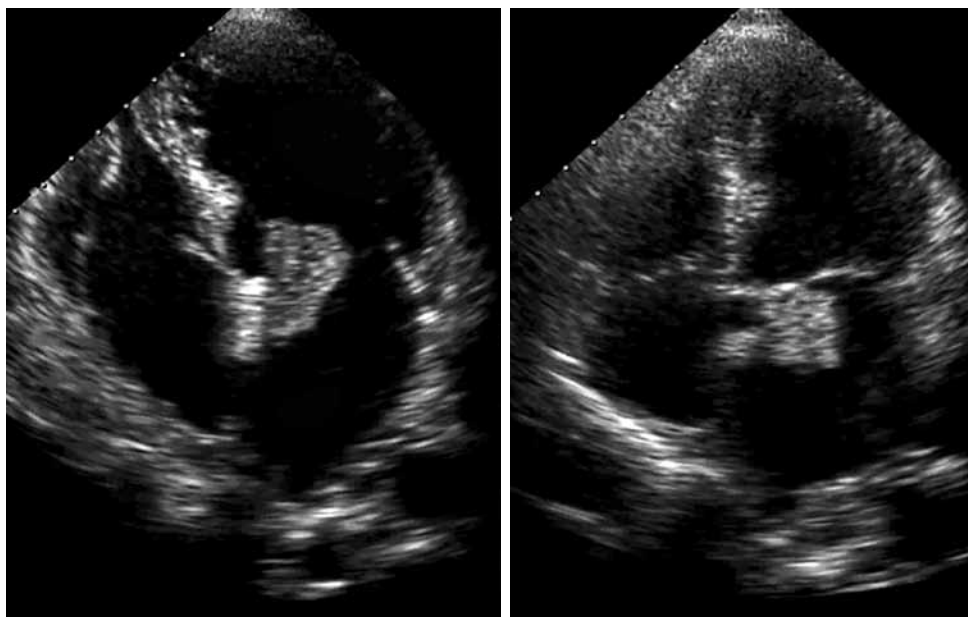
Echocardiography shows a myxoma in the left atrium which is prone to move toward the left ventricle.
